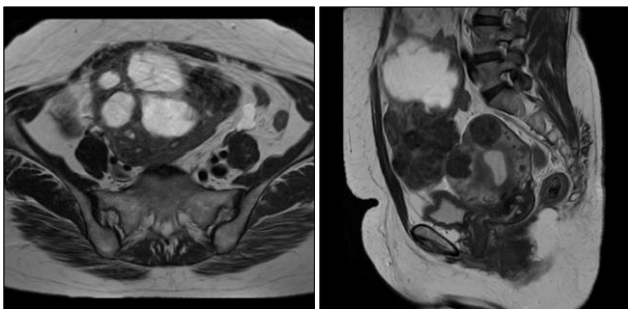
Axial and sagittal T2 Weighted MRI images showing pedunculated mixed solid and cystic mass lesion in the pelvis arising from the fundus of uterus in a 47 year old female patient with multiple intramural and subserosal uterine leiomyoma's.
